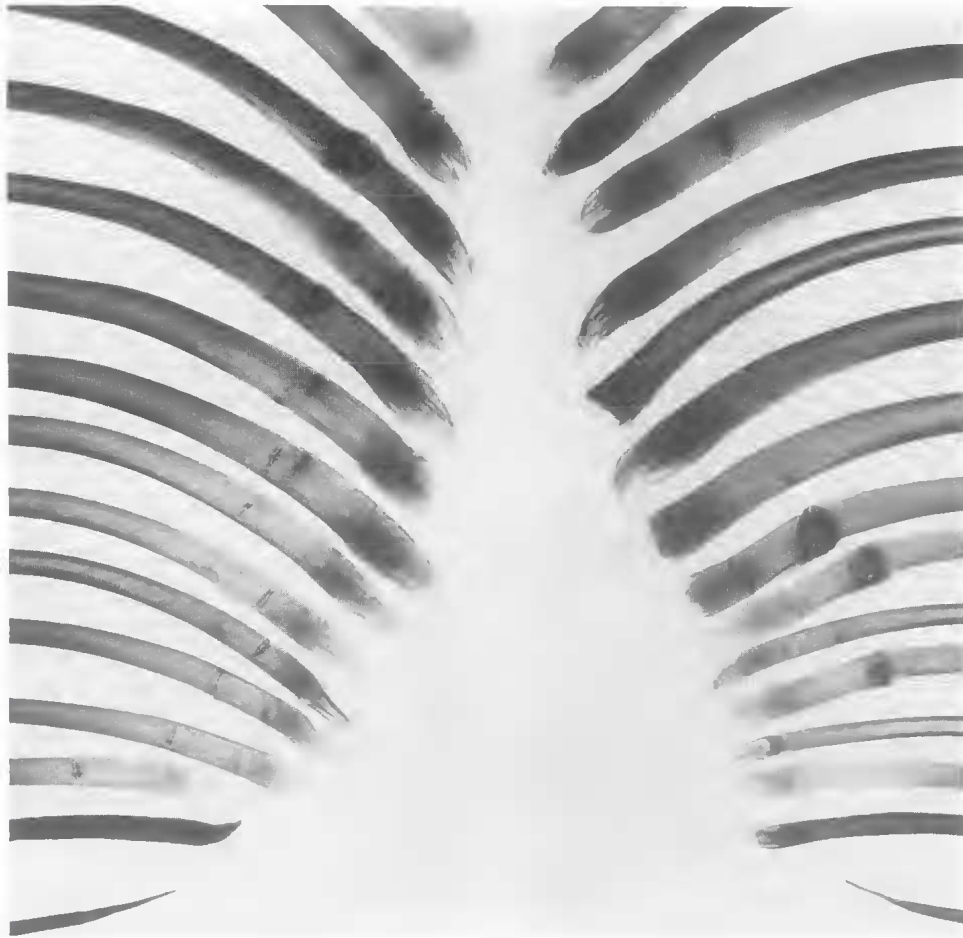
Humpback whale QMJM7303. Radiograph demonstrating healing undisplaced bilateral ventral rib fractures. The sternum has not been included. (The vertical 'tracks' in some ribs on the left of the photograph result from drilling to insert numbering wires).
